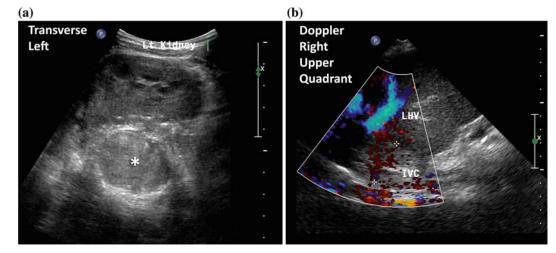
An 11-year-old female presented with a large left sided abdominal mass. A CT scan and MRI were performed which demonstrated a left adrenal primary tumor with tumor extension through the adrenal veins into bilateral renal veins, hepatic veins, IVC, and into the right atrium. Her treatments consisted of biopsy, neoadjuvant chemotherapy, resection of primary and thrombus under
